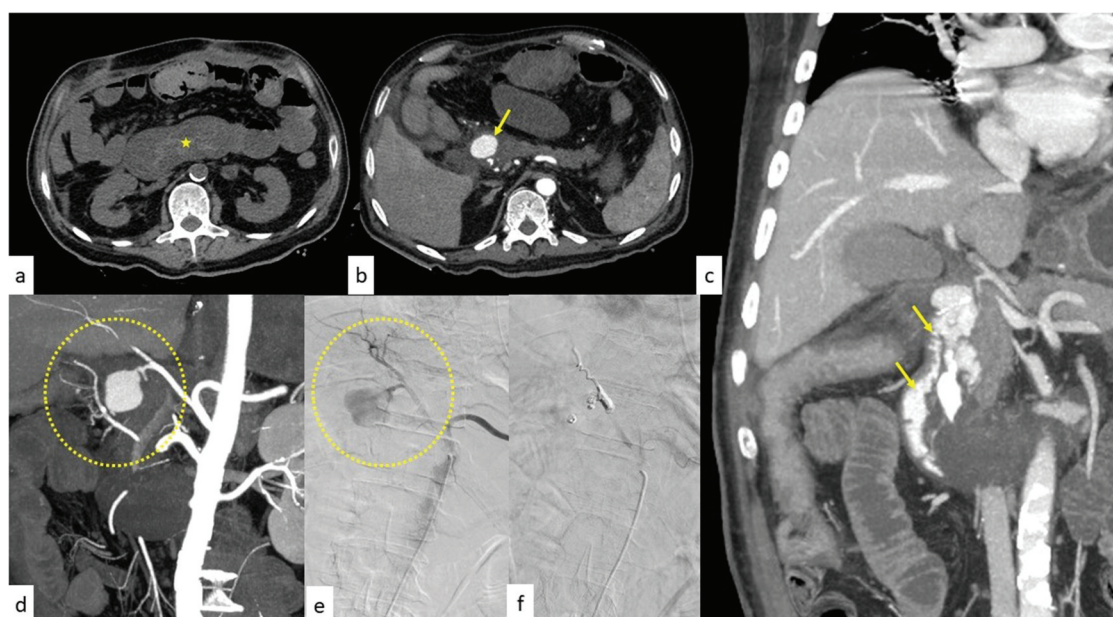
Post-endoscopy multidetector-row computed tomography angiography in a patient with clinically severe non-variceal upper gastrointestinal bleeding due to a giant duodenal ulcer refractory to endoscopic hemostasis. The unenhanced phase (a) demonstrates a spontaneously hyperdense intraluminal area in the stomach and duodenum (star), consistent with a sentinel clot. In the arterial phase (b), an active blush of contrast medium is detected within the gastric lumen (arrow), with progressive increase in the venous phase (c, arrow). Selective angiography confirmed the ct findings, showing prominent gastric arterial extravasation (d, dashed circle), followed by successful embolization (e). Informed patient consent was provided for the publication of these images.
